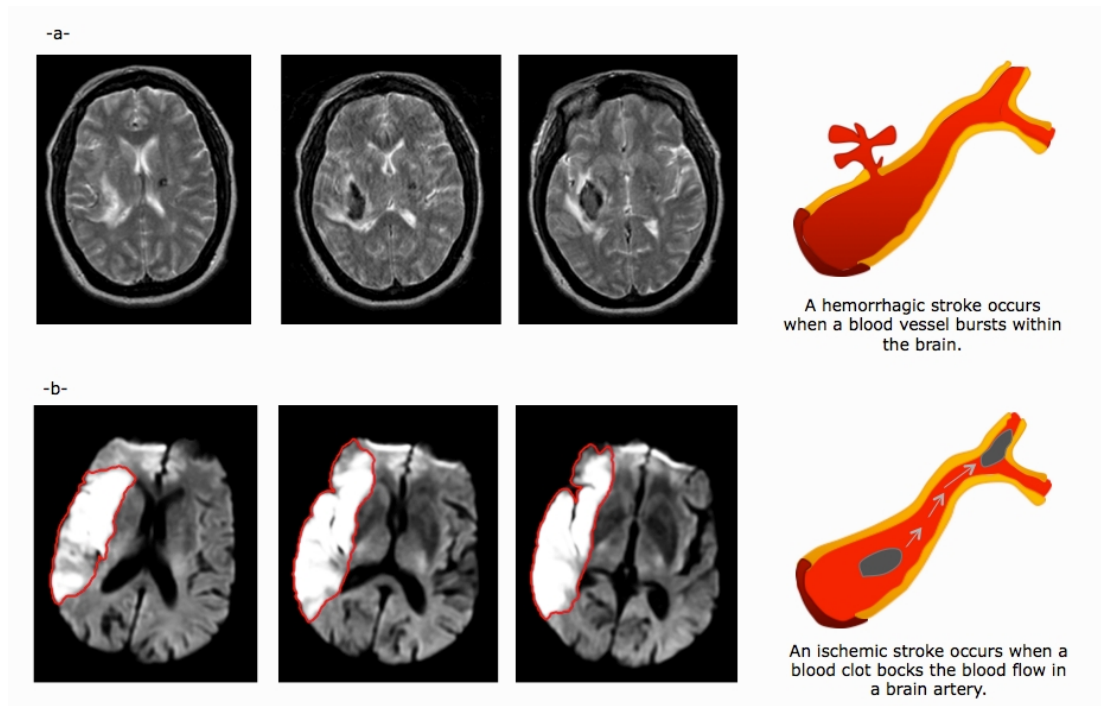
Subtypes of stroke.* (a) Three axial slices from a T2-weighted MR brain scan showing a decrease in signal indicating a recent hemorrhagic stroke in the posterior aspect of the right lentiform nucleus. (b) Axial slices showing an ischemic stroke lesion on MR diffusion weighted imaging.
